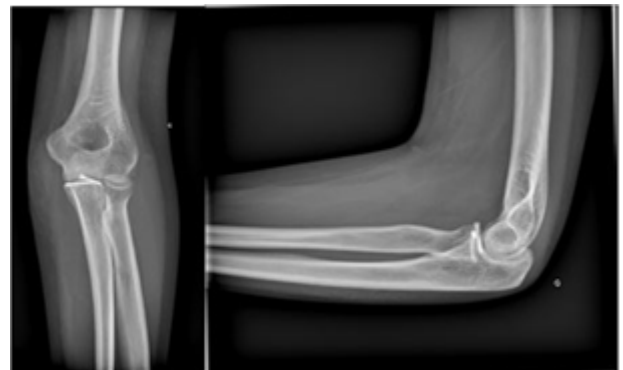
Antero-posterior and lateral X-rays at 3 months post-operatively demonstrate concentric reduction of the elbow joint.
